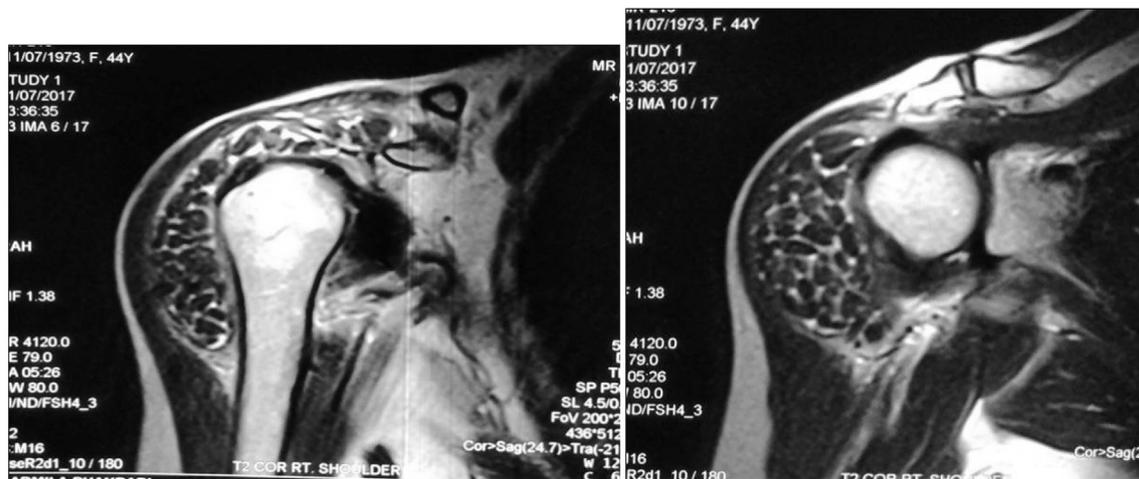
a & 3b: Coronal T2-weighted MRI images of right shoulder showing distended subacromial–subdeltoid bursa filled with fluid and multiple small well defined hypointense intrabursal loose bodies.
